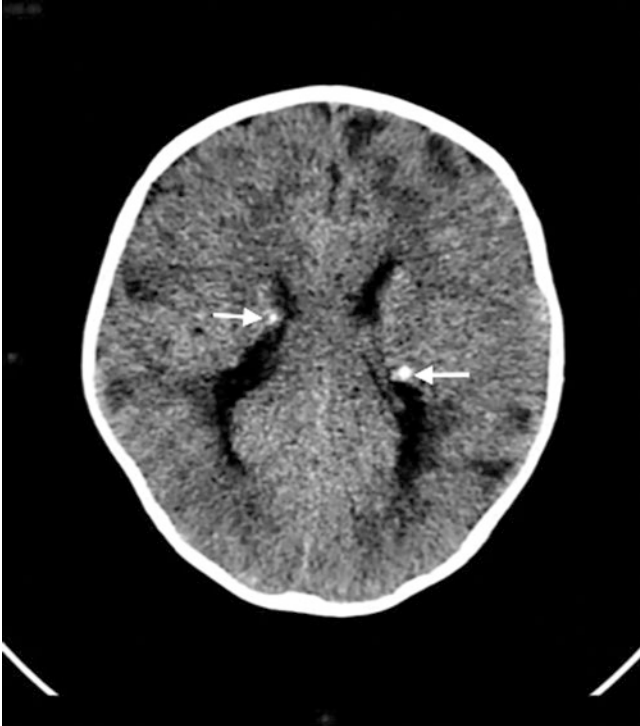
Axial CT image shows calcified subependymal nodules (arrows) along the walls of the lateral ventricles in a patient with tuberous sclerosis. Cortical tubers are identified as areas of low attenuation within the brain parenchyma bilaterally
